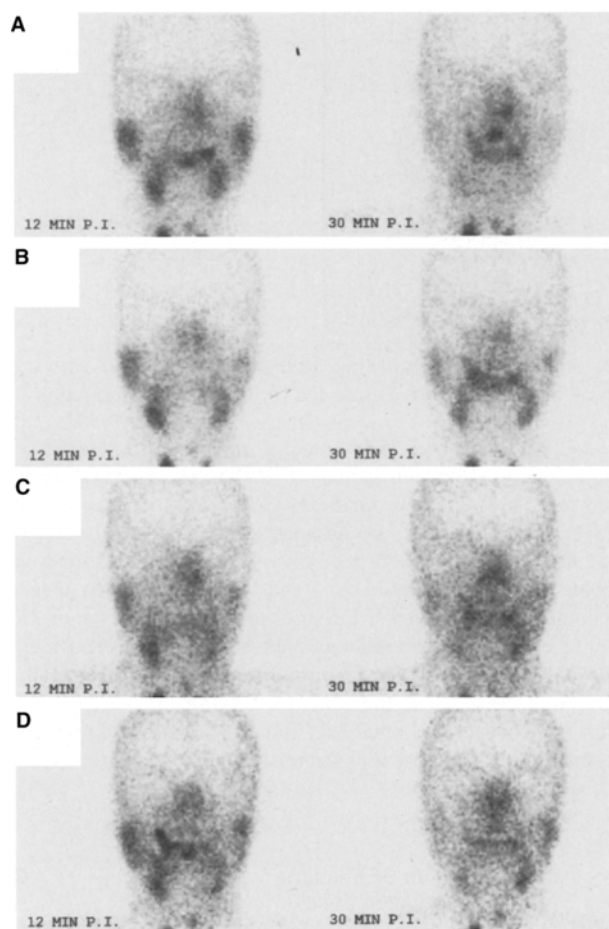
Sequential salivary gland ^{99m}Tc -pertechnetate scintigrams (A before radiotherapy, B 1 month after radiotherapy, C 6 months after radiotherapy, D 12 months after radiotherapy) of a patient with a squamous cell carcinoma of the left tonsil showing decreased excretion response in the salivary glands of the left side, which received higher radiation doses, especially after 6 and 12 months
